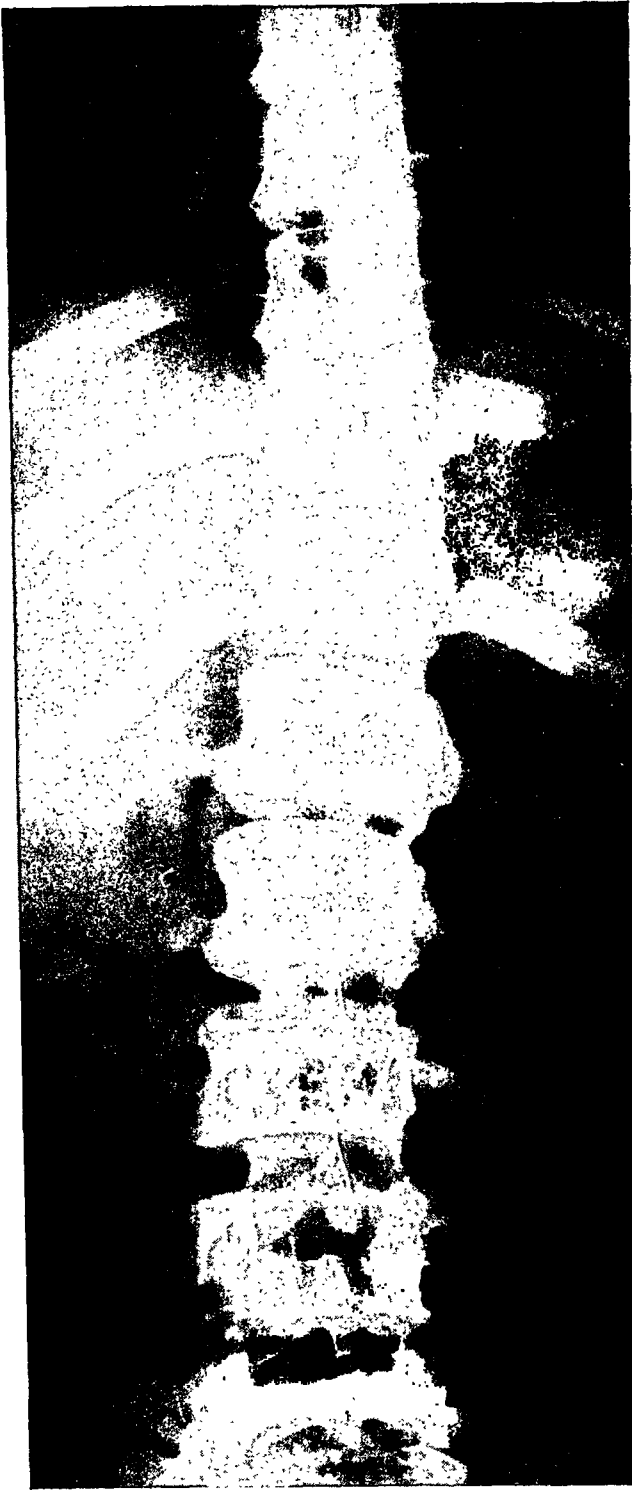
Case IV. Anteroposterior roentgenogram of the spinal column showing the narrowing of the pedicles and dilatation of the spinal canal in the upper lumbar region. The interpedicular distances measured: thoracic 6, 18 mm.; 7, 19 mm.; 8, 20 mm.; 9, 22 mm.; 10, 25 mm.; 11, 26 mm.; 12, 33 mm.; lumbar 1, 40 mm.; 2, 33 mm.; 3 and 4, 30 mm.; 5, 33 mm.
